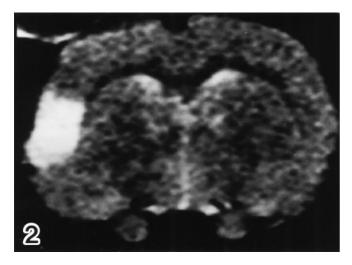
Coronal T2-weighted image at the level of the anterior hypothalamus at 24 h after impact. The localized area in the impact site, parasagittal cortex and hippocampus increased signal intensities
